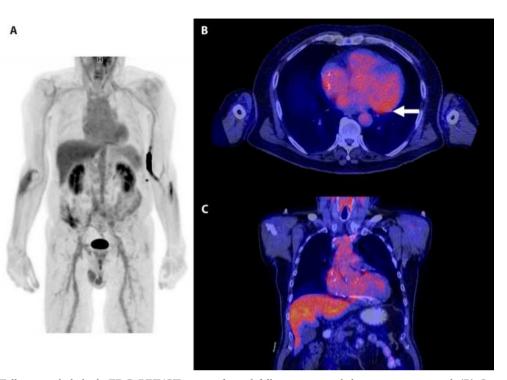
(A) Follow-up whole body FDG-PET/CT was performed following myocardial suppression protocol. (B) Overall, there was complete resolution of the multiple foci of intense FDG uptake in the myocardium with the exception of a low-grade area of uptake (SUVmax=3.5) within the basal anterolateral segment (white arrow), representing non-specific activity probably related to sub-optimal suppression. (C) Uptake within intrathoracic LN also completely resolved.
